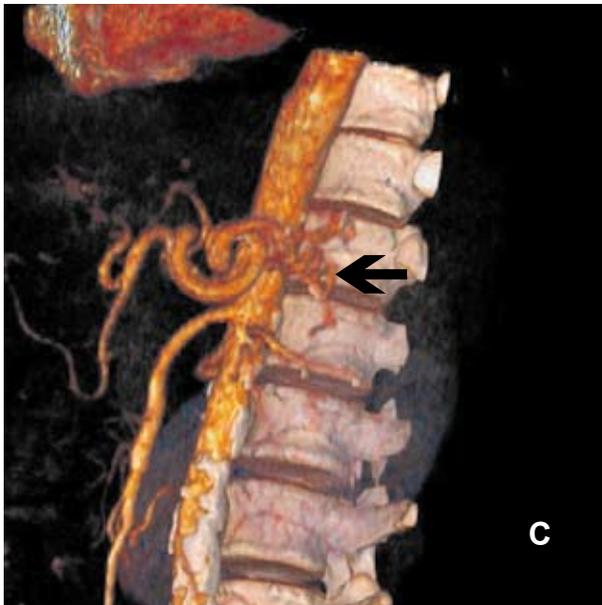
(A) Computed tomography (CT) angiography axial slice maximum intensity projection (MIP). Arterial phase with active hemorrhage from splenic artery; (B) multislice CT scan in coronary projection; MIP. Active bleeding from splenic artery in the hematoma formed between the tail of the pancreas and the hilum of the spleen; (C) CT angiography with volume rendering (VRT): celiac trunk with tortuous splenic artery.
